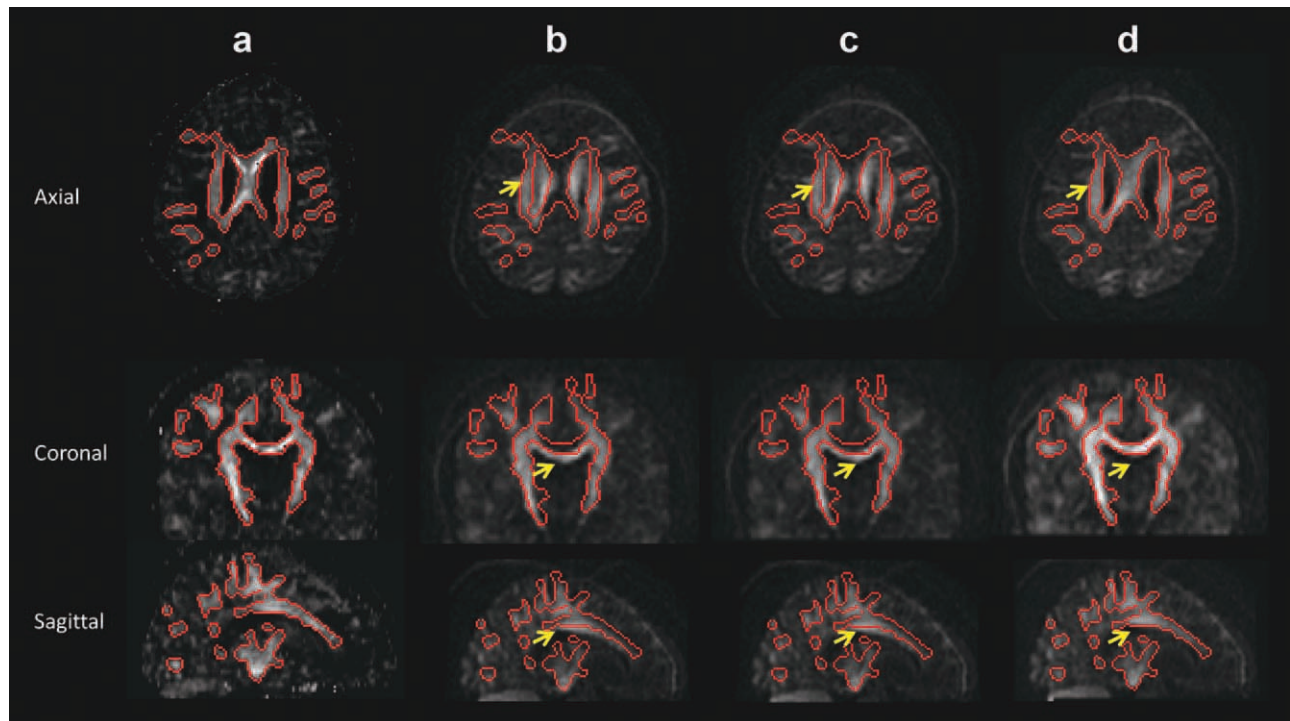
A representative example for the proposed high b -value registration procedure. a: High b -value template image ($b = 3990$ s/mm², gradient direction:[-0.241, 0.931, 0.132]) compared with (b) the original acquisition at the same gradient direction, (c) the same image corrected with respect to the nondiffusion image (using SPM2 with a normalized mutual information cost-function), and (d) the corrected image following UNDISTORT. The outline of the white matter, as detected in the template image, was superimposed on the original and corrected images. The yellow arrows indicate regions of motion artifact in the acquired DW-MRI. Note the white matter outlined in red in the corrected volume with respect to the template image. [Color figure can be viewed in the online issue, which is available at wileyonlinelibrary.com.]
